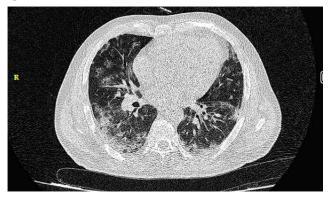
Chest CT showing peripheral dominant consolidations and parenchymal ground glass opacities consistent with COVID-19 pneumonia
